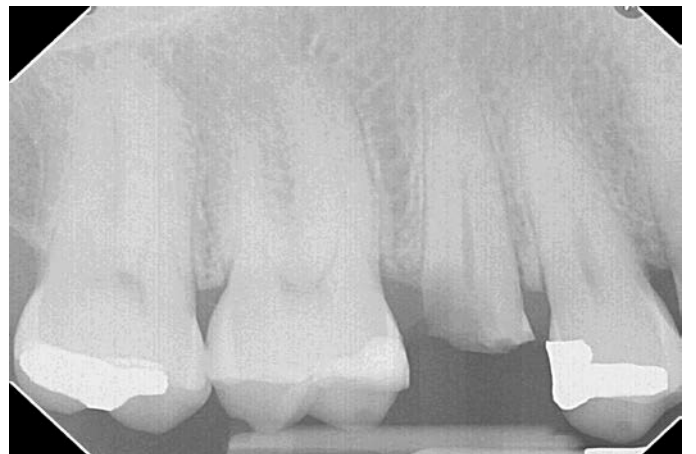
Intraoral Periapical view
